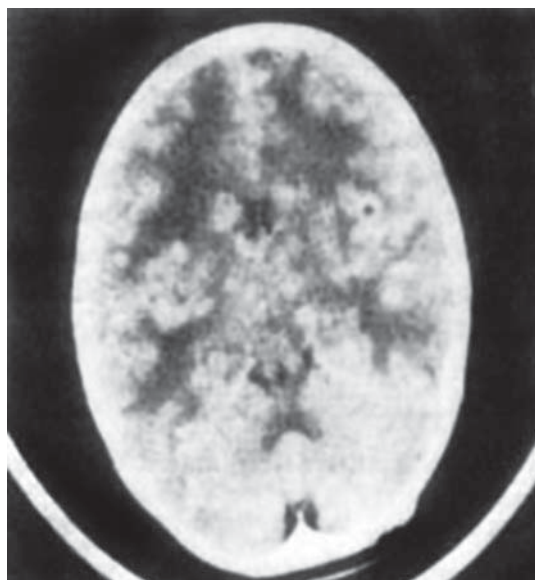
Computed tomography scan showing cerebral abscess in left frontal lobe.
